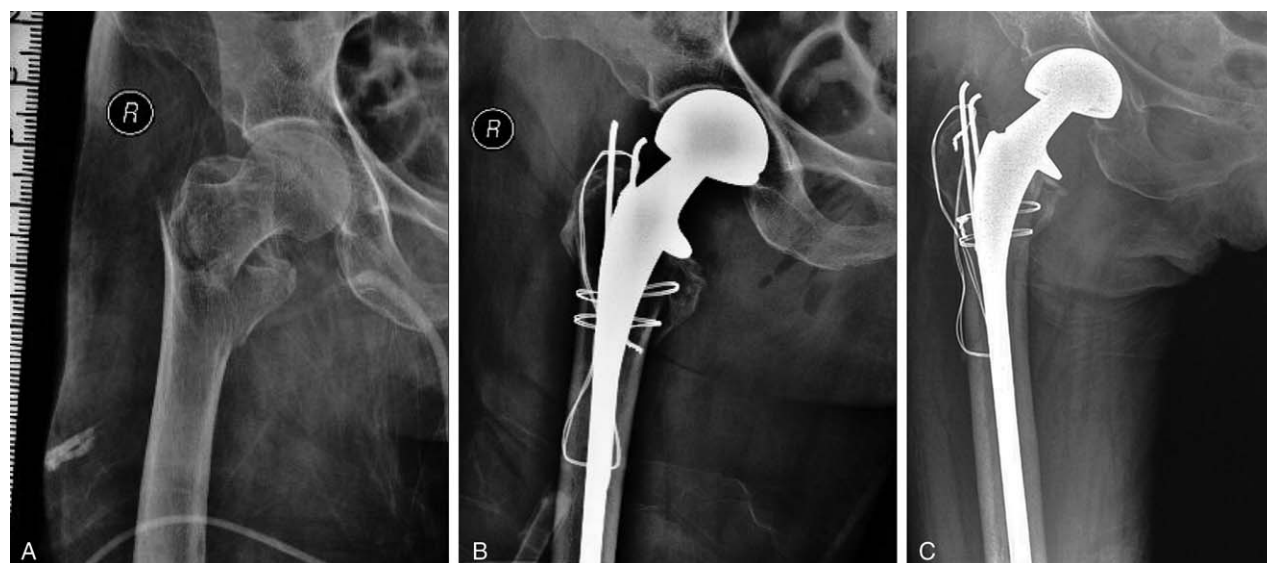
(A) Preoperative anteroposterior radiograph showing an unstable intertrochanteric osteoporotic fracture; (B) 2 days postoperative radiograph demonstrating a hip replacement with satisfying reduction and rigid fixation of the great and lesser trochanters with Kirschner-wires and tension band; (C) 1-year postoperative radiograph demonstrating a bone union of the greater and lesser trochanters.
